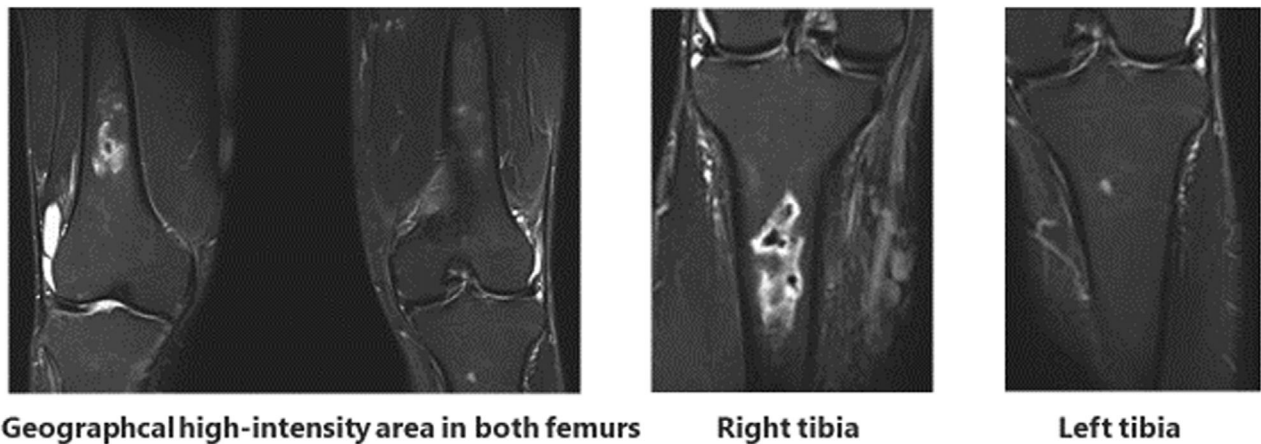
The magnetic resonance imaging (MRI) images taken 7 weeks from the onset.
